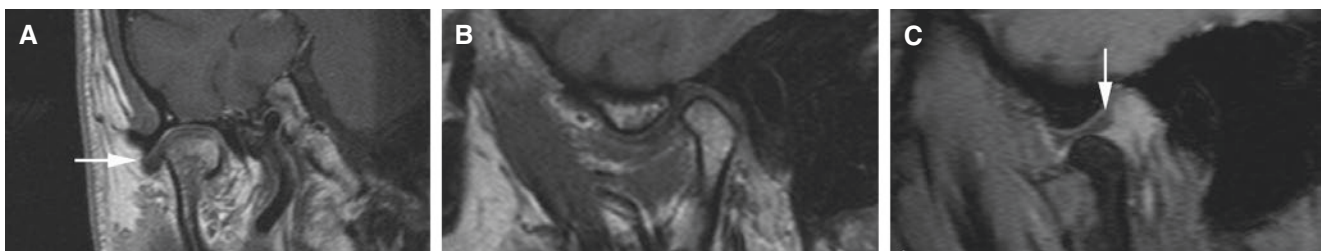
Partial disc displacement, normal bone; 65-year-old male. (A) Oblique coronal T1-weighted post-Gd MRI shows laterally displaced disc (*arrow*). (B) Oblique sagittal T1-weighted MRI shows apparently
